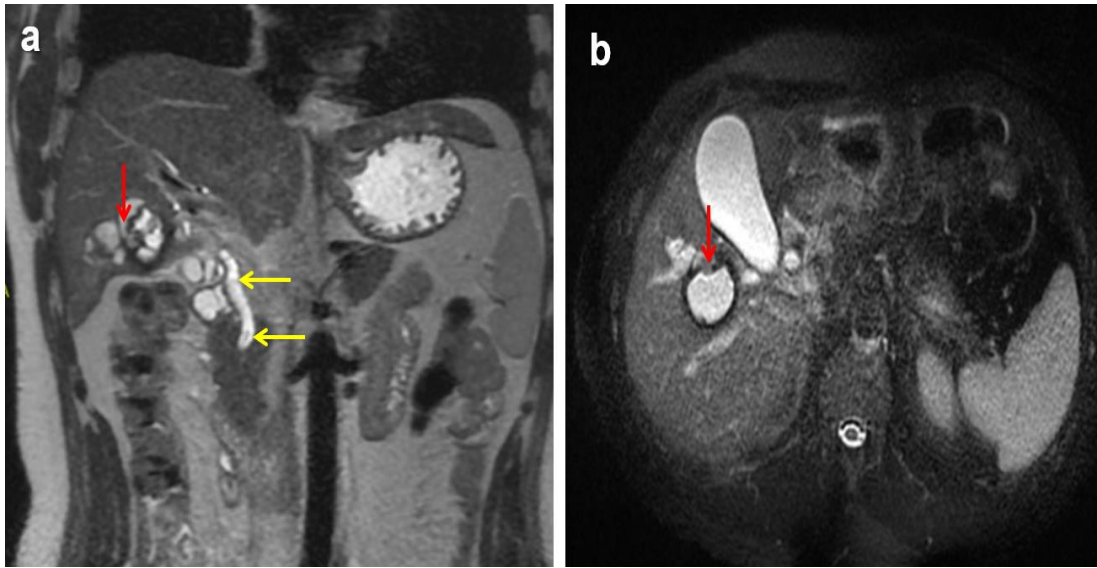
Coronal (a) and axial (b) T2-weighted MR images show the junction between the cyst and the biliary tract (red arrows). Also, the coronal T2-weighted image (a) shows enlarged common bile duct and filling defects of the cyst in the lumen (yellow arrows)
